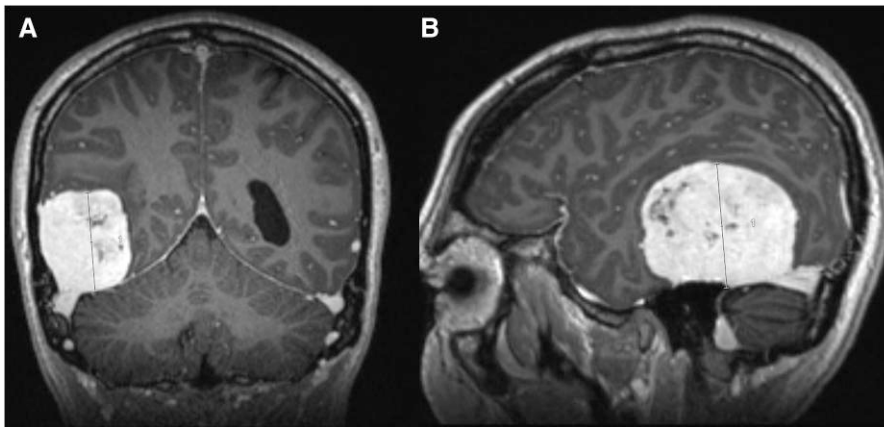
MRI brain demonstrating a right posterior temporal giant meningioma measuring 57 × 46 × 41 mm. A, Coronal view (T1-weighted); B, Sagittal view (T1-weighted).
